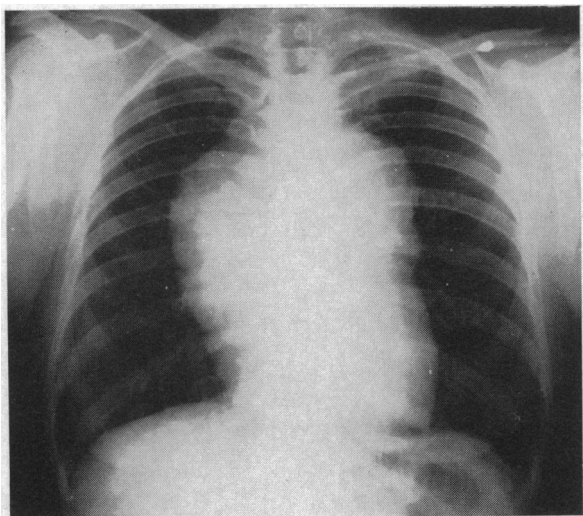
Roentgenogram of the chest, 17 February 1954, showing a large lobulated anterior-superior and anterior-middle mediastinal mass.
